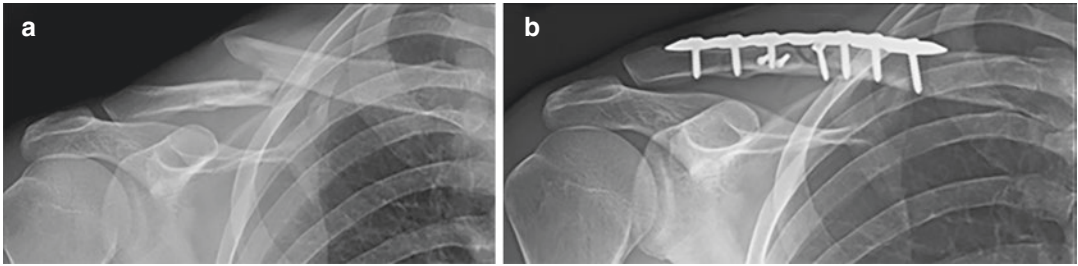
Standing radiographs of a displaced right clavicle fracture. Image (a) is a right shoulder antero-posterior radiograph demonstrating a displaced clavicle fracture.
